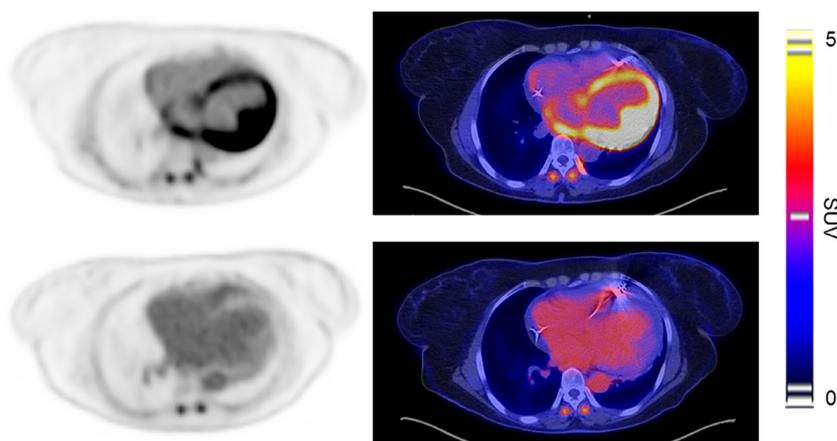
PET (left) and fused (right) FDG-PET/CT images of a patient before (top) and after (bottom) adequate myocardial suppression preparation including of prolonged fasting, high-lipid low-carbohydrate diet, and intravenous heparin injection. Without optimal preparation, evaluation of coronary inflammation can be challenging, if not impossible, due to high adjacent myocardial activity.
